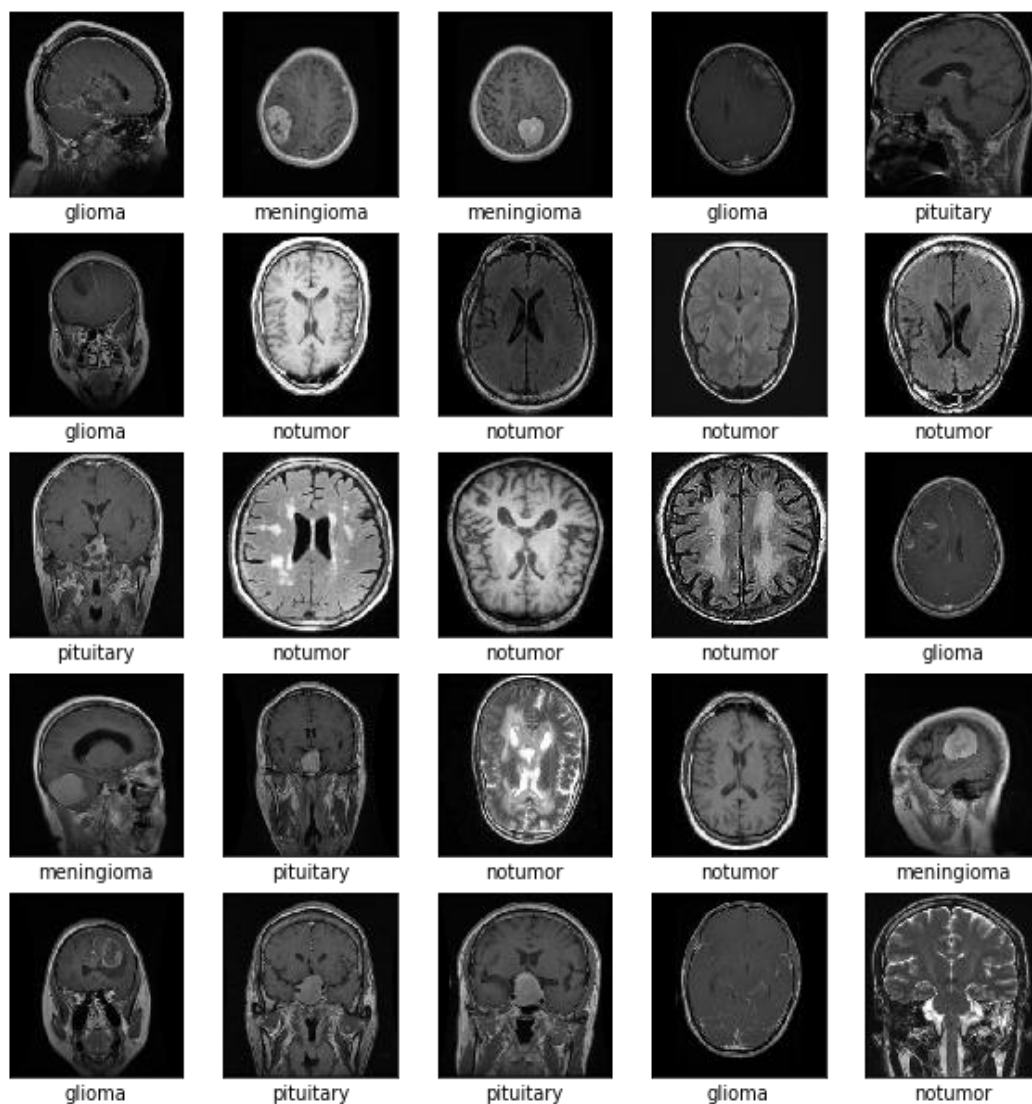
sample MRI image of human brain image.
